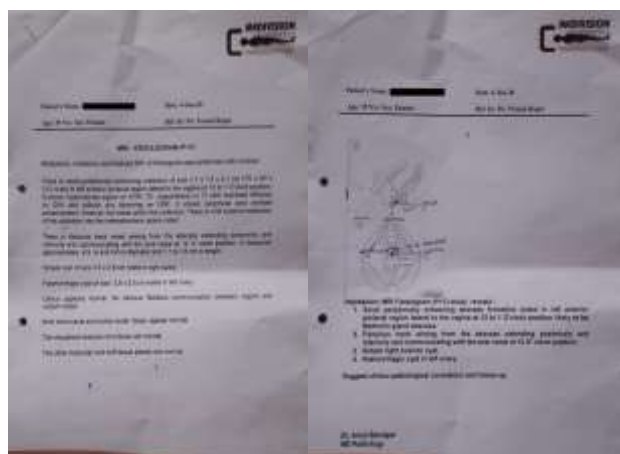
The magnetic resonance imaging-fistulogram.
